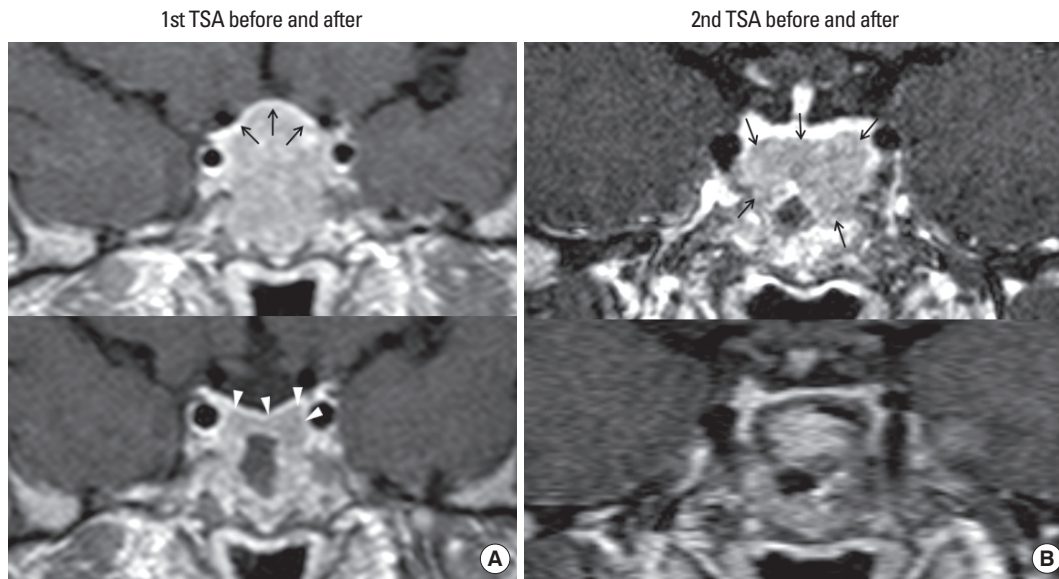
A coronal view of TSH-secreting macroadenoma by MRI, which was taken before and after the surgery. A. About 30 mm sized macroadenoma displacing the enhanced pituitary gland cranially (arrows) before the first TSA (upper panel) and residual tumor (arrow heads) after the first TSA (lower panel). B. About 20 mm sized macroadenoma (arrows) at the floor of pituitary fossa before the second TSA (upper panel) and completely resected tumor after the second the TSA (lower panel). TSA, trans-sphenoidal surgery; TSH, thyroid stimulating hormone.
